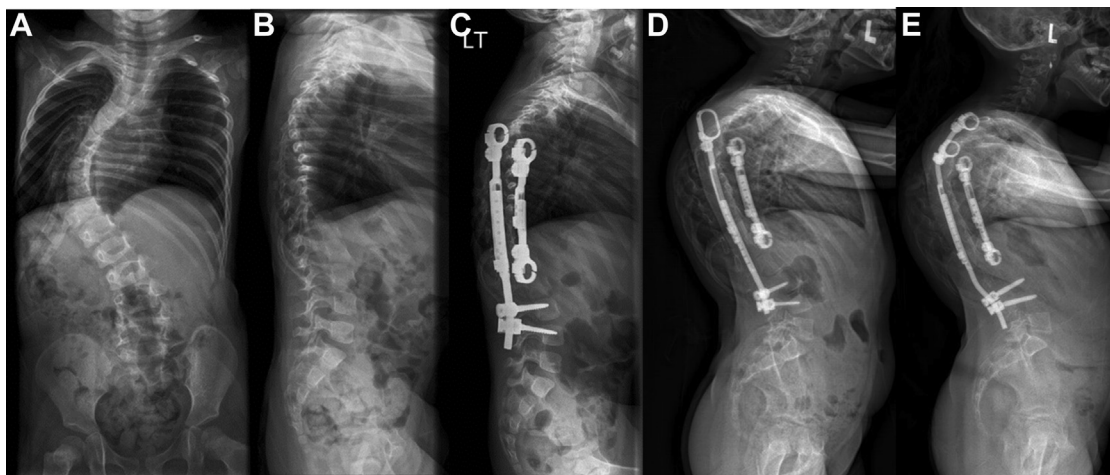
Two-year-old patient with infantile idiopathic scoliosis treated with rib-based distraction surgery that developed clinically significant PJK. (A) Pre-implantation supine posteroanterior scoliosis radiograph. (B) Preimplantation lateral scoliosis radiograph. (C) Initial postimplantation lateral scoliosis radiograph. (D) Five years postimplantation (eight lengthening surgeries and two exchange surgeries) with lateral radiograph demonstrating radiographic PJK. (E) Seven years postimplantation lateral radiograph demonstrating treatment of PJK with superior extension of the upper instrumented vertebrae. PJK, proximal junctional kyphosis.
